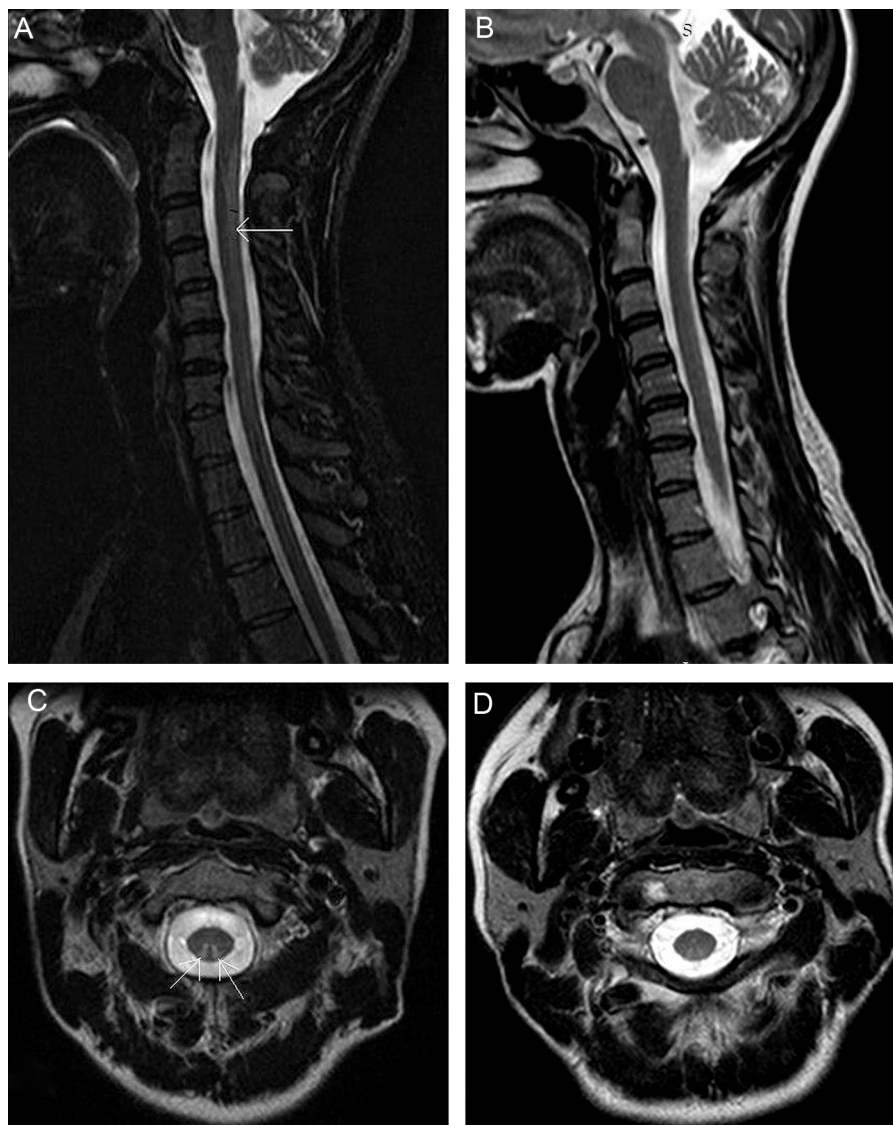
(A) Sagittal T2-weighted MRI of the cervical spine: linear increased T2 signal (arrow) in the posterior surface of the cervical cord from C2 to C7-Th1 (March 2013) and follow-up MRI, (B) without evident changes (October 2013), (C) axial T2-weighted image shows the signal hyperintensity (arrows) located symmetrically in the dorsal columns and follow-up MRI with slightly hyperintensity signal in dorsal column (D).
